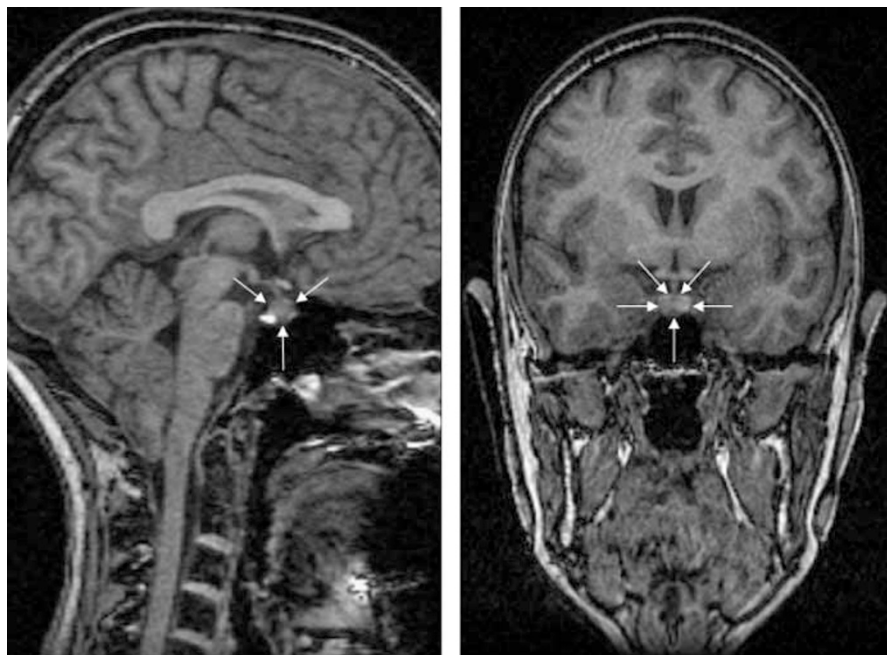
The pituitary gland in a sagittal (left) and coronal (right) MRI image. Coronal slices were used for the tracing of the pituitary, and the pituitary boundaries are indicated by the arrows. The pituitary stalk was not included in the tracings.
